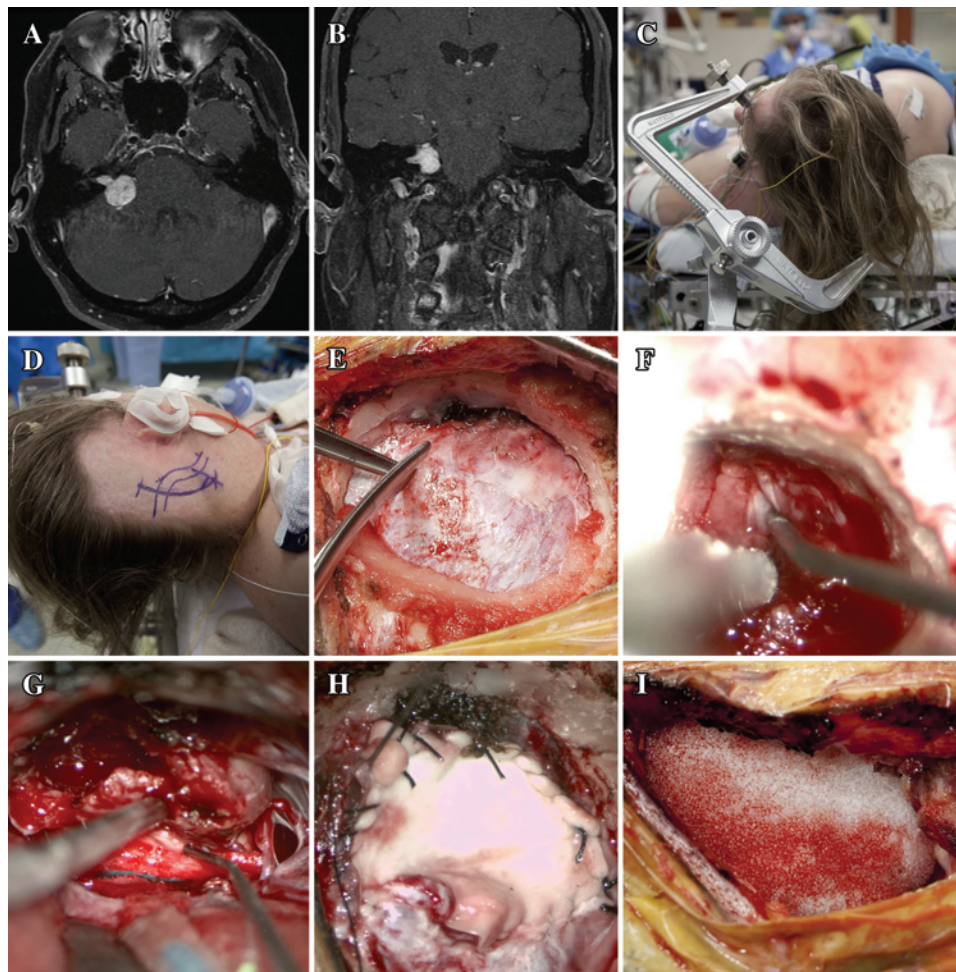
Axial (A) and coronal (B) T1-weighted MRI studies with contrast enhancement showing a VS occupying the right CPA and extending into the IAC of a 59-year-old woman. She presented with a history of tinnitus and decreased hearing in the right ear, and her audiogram showed that she had serviceable hearing on the right side. C–I: Intraoperative photographs obtained during the retrosigmoid approach to the tumor. C: The patient is placed supine or in the lateral position, and the head is fixed in a Mayfield 3-point head holder. D: The incision is located approximately 2 fingerbreadths behind the pinna of the ear. The planned suboccipital craniectomy exposes the edges of the transverse and sigmoid sinuses. E: The dura is opened parallel to the sinuses and then retracted with 4-0 silk sutures. F: The posterior lip of the IAC is drilled, the vestibular nerves are divided, and the facial nerve is identified anterior to them and confirmed with stimulation. The cochlear nerve is identified just inferolateral to the facial nerve. G: The tumor is then dissected off the cerebellum and brainstem and debulked using the ultrasonic aspirator. The root entry zones of the facial and cochlear nerves at the brainstem are identified, and the facial nerve is confirmed with stimulation. The tumor is dissected off these 2 nerves very carefully and under direct vision. H: After tumor removal, the dura is closed in a watertight fashion by using an AlloDerm patch. I: The bone defect is covered with Medpor cranioplasty (porous polyethylene implant).
